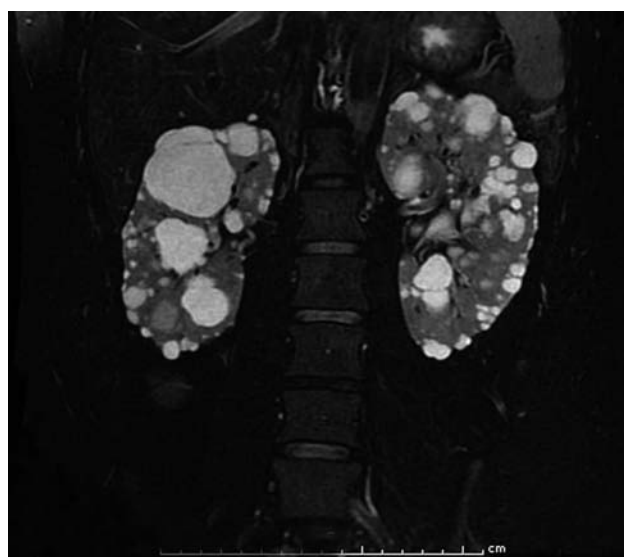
Magnetic resonance imaging of the renal artery revealed innumerable cysts, causing diffuse enlargement of both kidneys. The cysts ranged from subcentimeter size to the largest diameter of 5.3 cm. The largest cyst is seen at the upper pole of the right kidney, which had thin septation. Also, there were multiple small hepatic cysts ranging from tiny to 1.1 cm in diameter (not shown). Renal arteries and adrenal glands were normal (not shown).
